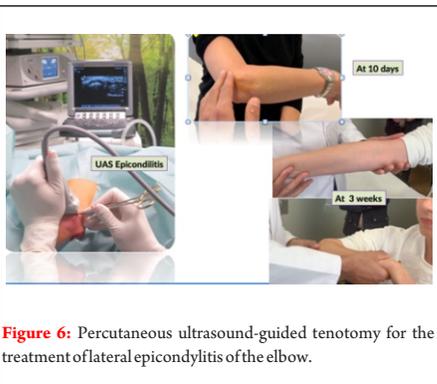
Percutaneous ultrasound-guided tenotomy for the treatment of lateral epicondylitis of the elbow.
